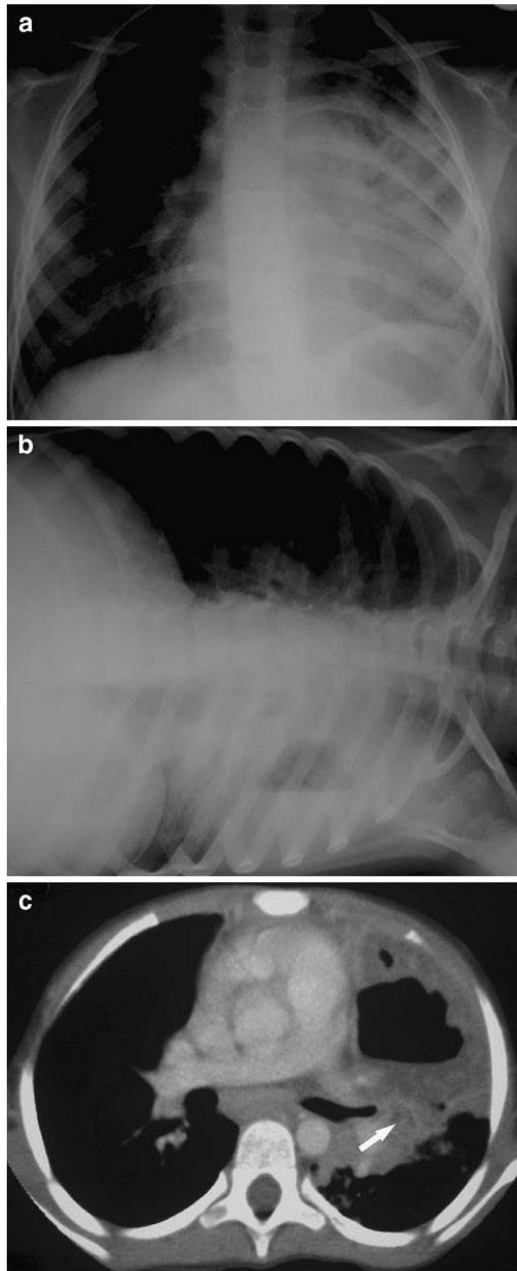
A 5-year-old HIV-positive child (TL) not receiving antiretroviral therapy. a The chest radiograph demonstrates dense airspace consolidation with breakdown in the left lower zone. b A decubitus view confirms an air-fluid level within a large thick-walled cavity. c CT demonstrates breakdown in an area of dense consolidation in the lingular region secondary to airway obstruction. Low-density rim-enhancing nodes (*arrow*) are seen at the left hilum
